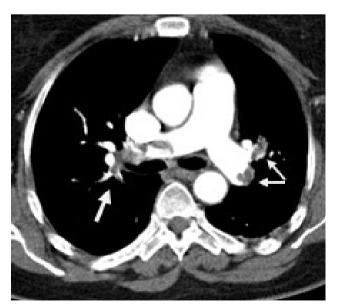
Chest CT scan. The arrows point to the thrombi on the pulmonary arteries.
